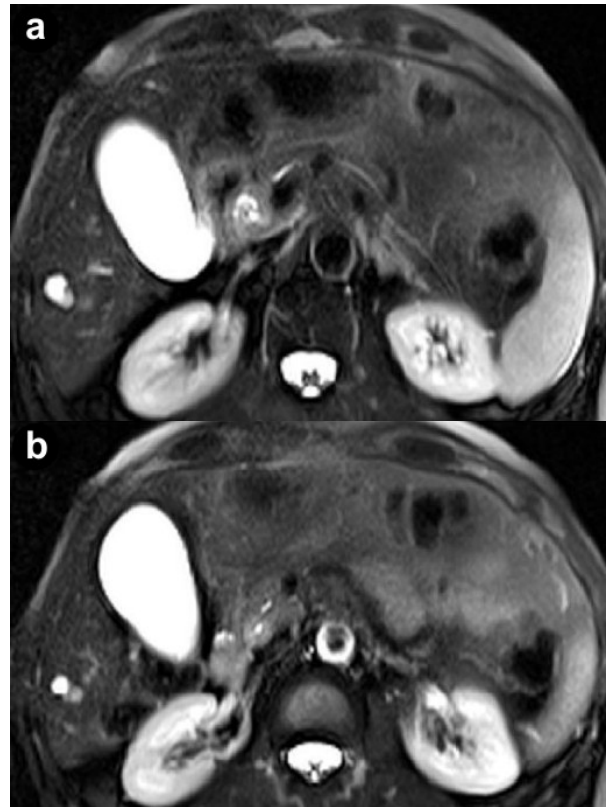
Cross-sectional T2-weighted fat-suppressed images. Axial T2-weighted turbo spin echo short-time inversion recovery (STIR) sequences show a circumferential wall-thickening of the common bile duct with a firm component projecting into the lumen.
